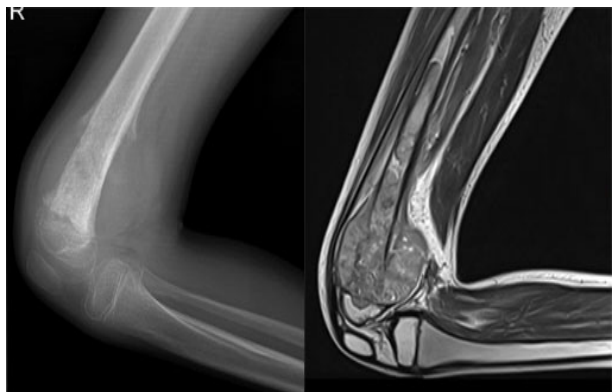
X-ray lateral right knee and corresponding MRI T2 sagittal images showing bone destruction, lamellated periosteal reaction and associated soft tissue component in metadiaphysis of right femur. Presumptive diagnosis of Ewing's sarcoma was made.
